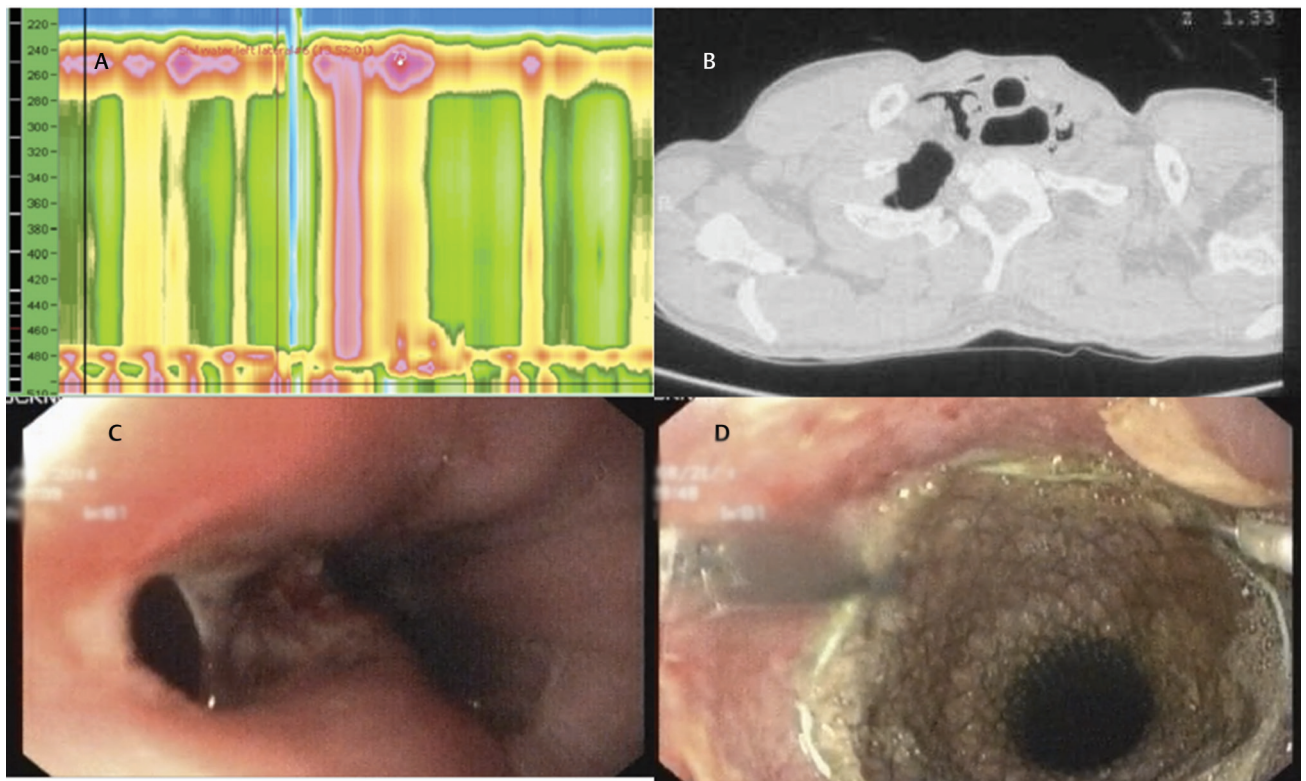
(A) Esophageal manometry suggestive of type II achalasia cardia; (B) computed tomography scan of thorax after pneumatic dilation showing pneumomediastinum; (C) rent seen in lower esophagus following pneumatic dilation; (D) Esophageal self-expanding metal stent with hemoclips.
